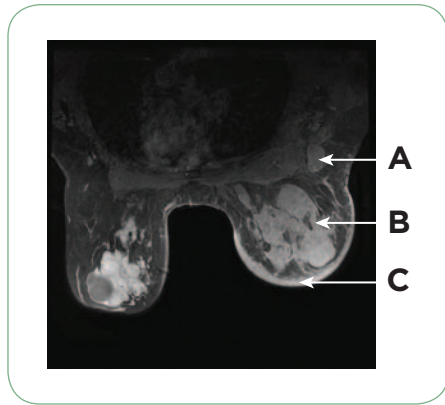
Breast MRI that shows axillary adenopathy (A), increased density (B), and diffuse skin thickening (C).
